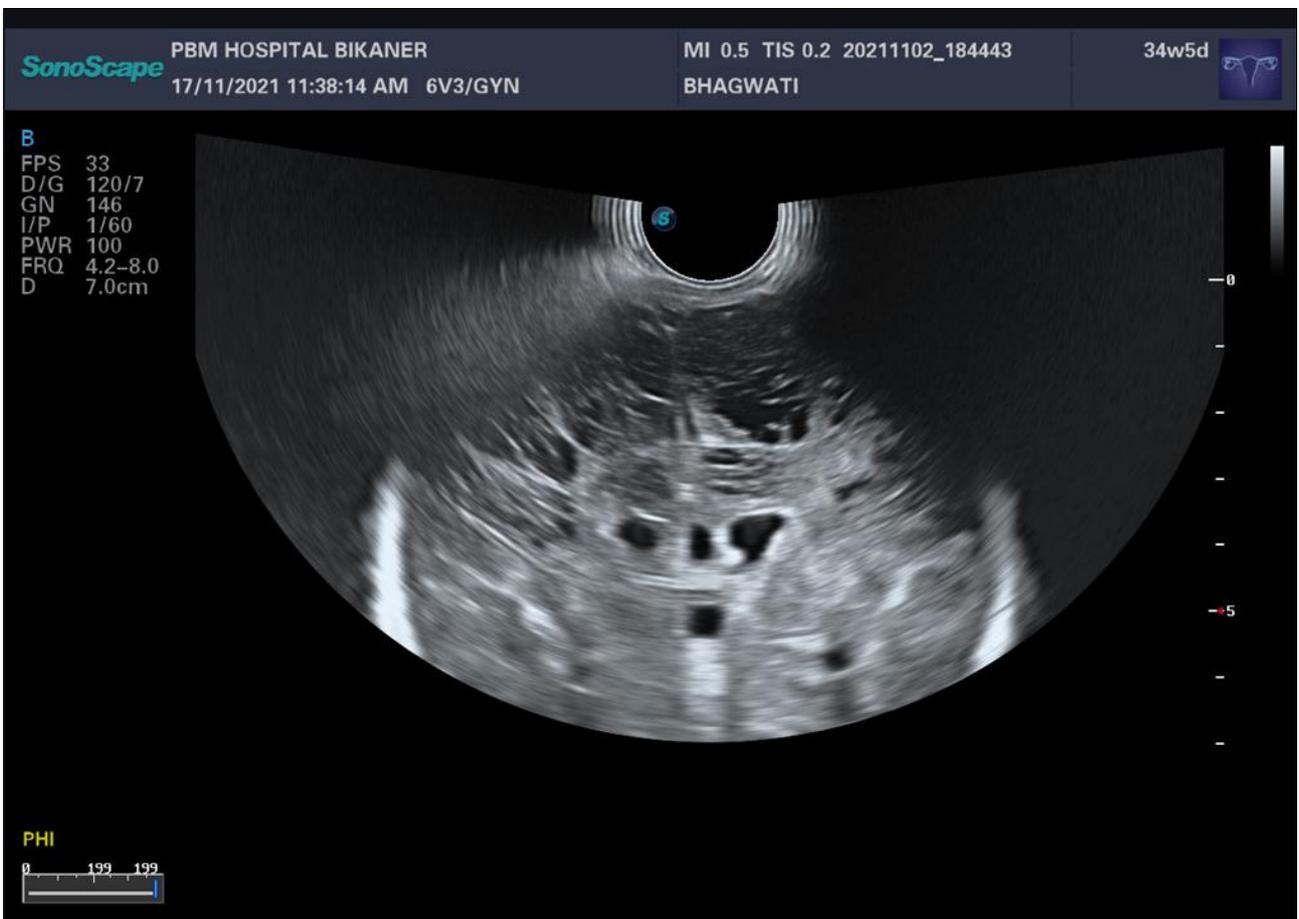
Neurosonogram showing pan ventriculomegaly.
